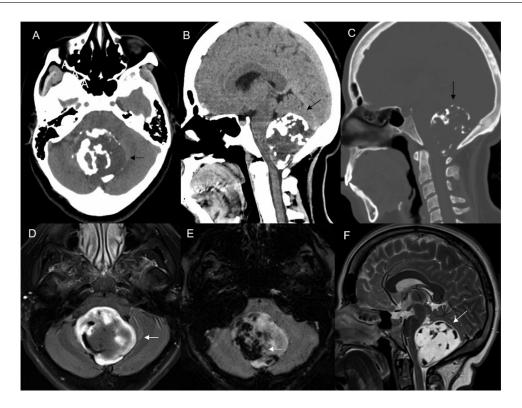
Case 1-Multiple CT images (A,B,C) reveal a large partially calcified lesion in posterior fossa in the region of cerebellar vermis (*black arrows*). MRI images (D,E,F) better characterizes the midline posterior fossa lesion centered along the cerebellar vermis (*white arrows*) with heterogenous T2 bright contents (F). Multiple areas of SWI dropout (*white arrow*) were noted within the lesion (E) corresponding to the calcification seen on prior CT.
